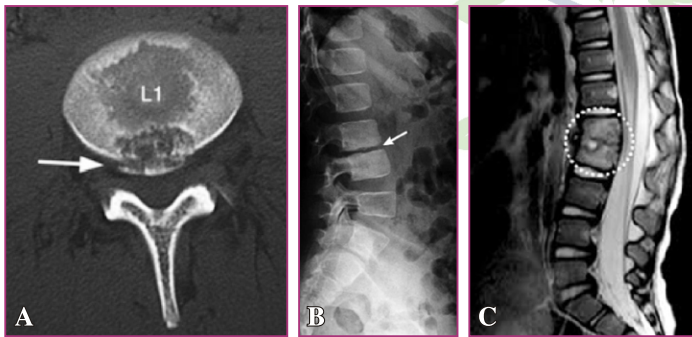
A : L1 – L2 DISC PROLAPSE: Axial CT of the spine demonstrating an apophyseal ring fracture (arrow).
